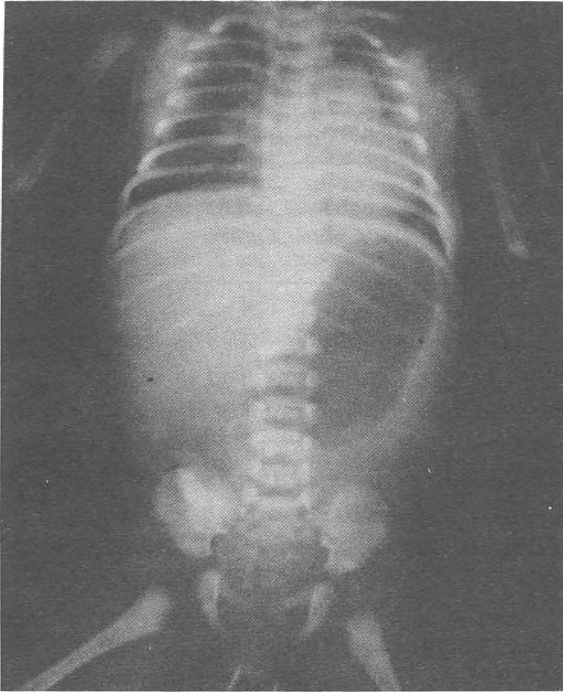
Plain antero-posterior x-ray film of the abdomen showing large, air-filled stomach without evidence of gas distally.
